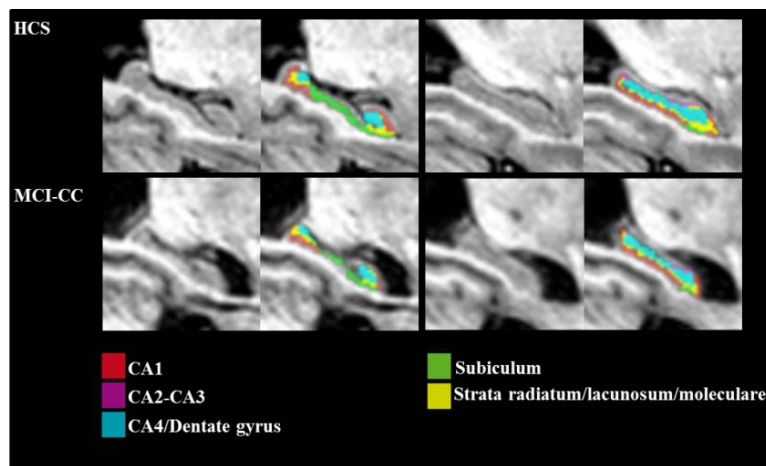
Automated segmentation of hippocampal subfields. CA = cornu ammonis. Coronal views of the hippocampus and hippocampal subfields in magnetic resonance images from a healthy control subject (HCS) and a mild cognitive impairment converter at time of conversion (MCI-CC).
